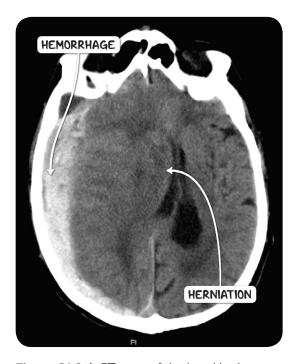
A CT scan of the head in the axial plane demonstrating a right sided acute subdural hemorrhage. The pressure effect has pushed the medial aspect of the right cerebral hemisphere underneath the falx cerebri, known as sub-falcine herniation.
